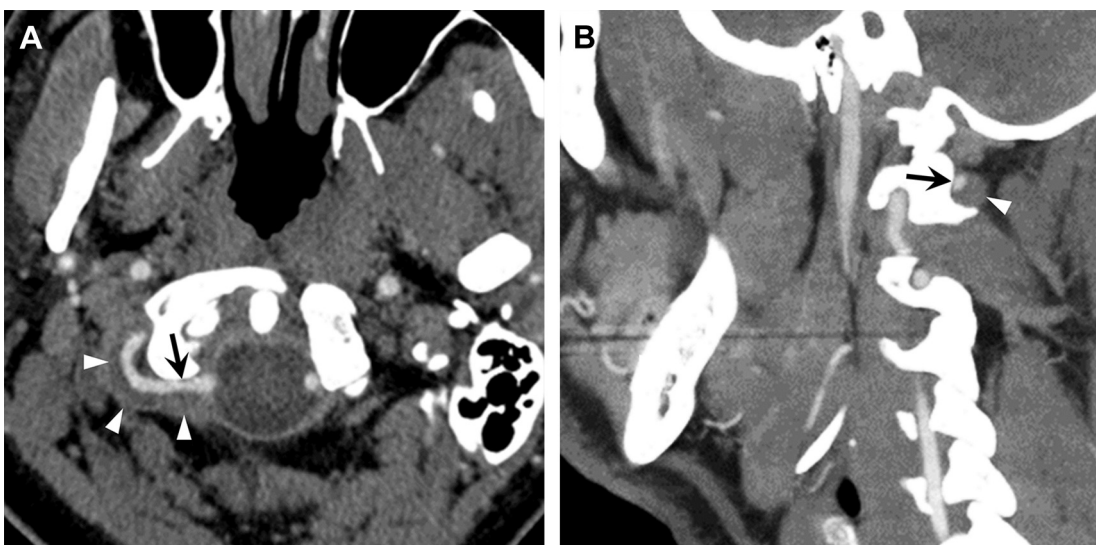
Traumatic right vertebral dissection and intramural hematoma. (A) Axial and (B) sagittal CTA images show mild compression of the true lumen of the V3 segment of the right vertebral artery (arrows) by an extensive intramural hematoma (arrowheads). (Courtesy of Rihan Khan, MD.)
